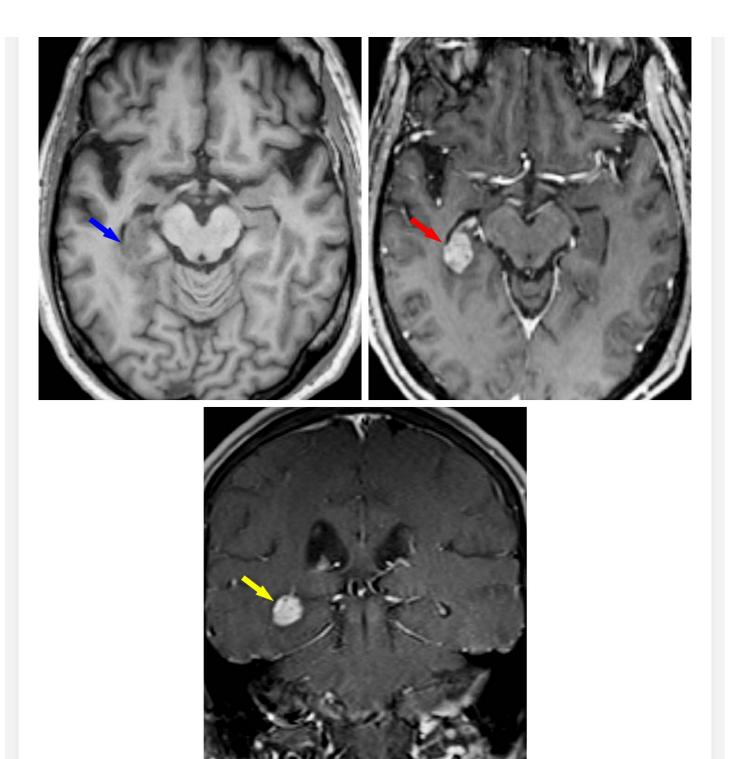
Intraventricular/choroid plexus metastasis. In this patient with a history of metastatic lung cancer, there is evidence of a right choroid plexus metastasis. (Top Left) Axial T1-weighted image without contrast, demonstrating a right choroid plexus lesion with intermediate T1 signal (blue arrow). After the administration of contrast, the lesion is much more clearly visible on axial (top right) and coronal (bottom) images as an avidly enhancing lesion with close association with the temporal horn choroid plexus.
